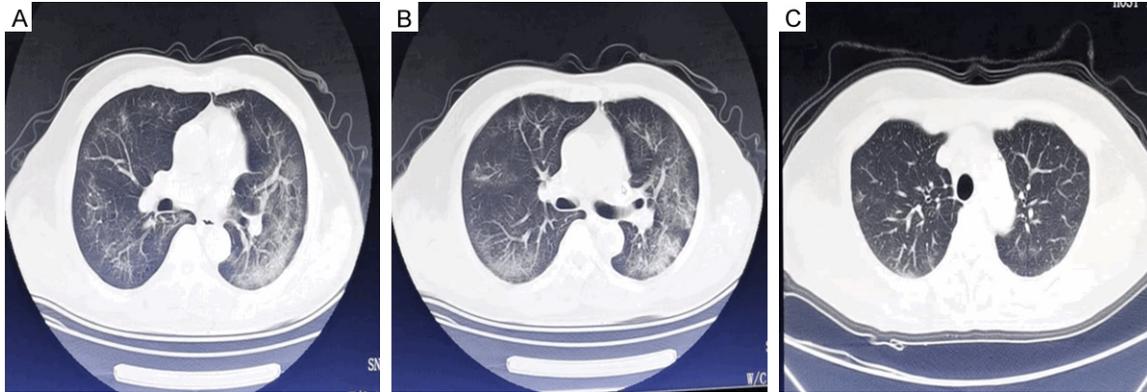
Chest CT scan from a 58-year-old COVID-19 male case without T2D, showing fever for nine days and breathing difficulty for five days. A. The first level. B. The second level. C. The third level.
